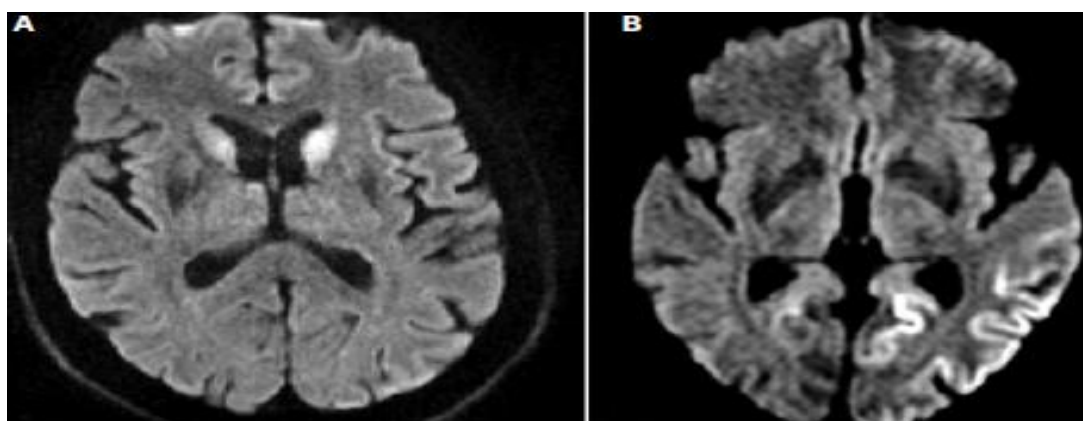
Cranial MRI. Hypersensitivity T2 signals located in the caudate nucleus on both sides of the brain tissues (A) and in the occipital lobe (B)
